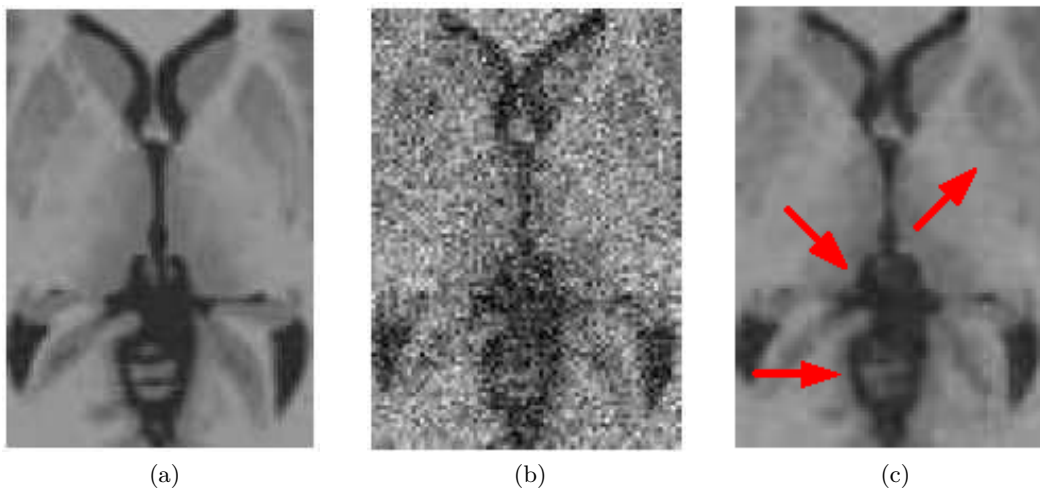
Application of NL-means filter to MRI brain images: (a) Input image; (b) Noisy image adding AWGN noise; (c) Image (b) restored by using the NL-means filter. The noise is sensibly reduced and the structures quite well preserved. However, in some areas indicated by red arrows a significant resolution loss is perceivable. The images are extracted from the paper by Coupé et al. (2008) and the arrows are added to facilitate our discussion.
